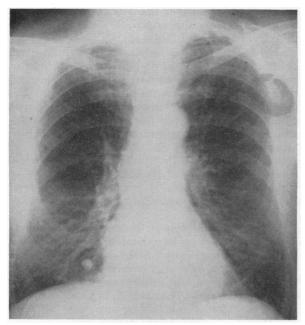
X-ray film showing mild increase in density throughout right middle lobe, interpreted as pneumonitis.
